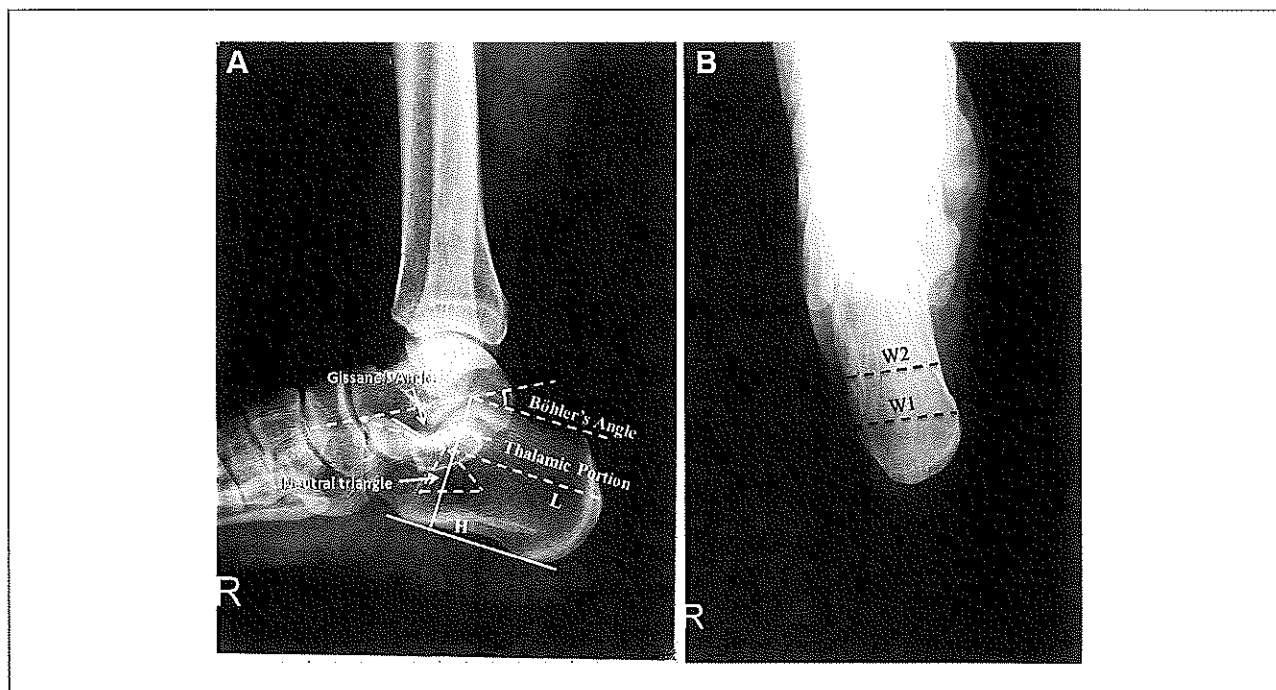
(A) Normal calcaneal lateral view radiography showing the measurements of Böhrer's angle and calcaneal length (L) and height (H). The thalamic portion, neutral triangle, and Gissane's angle are identified. (B) Normal axial view radiographs showing the widest (W1) and narrowest (W2) portion of the calcaneal tuberosity. The presented value (W) is the mean of W1 and W2.
